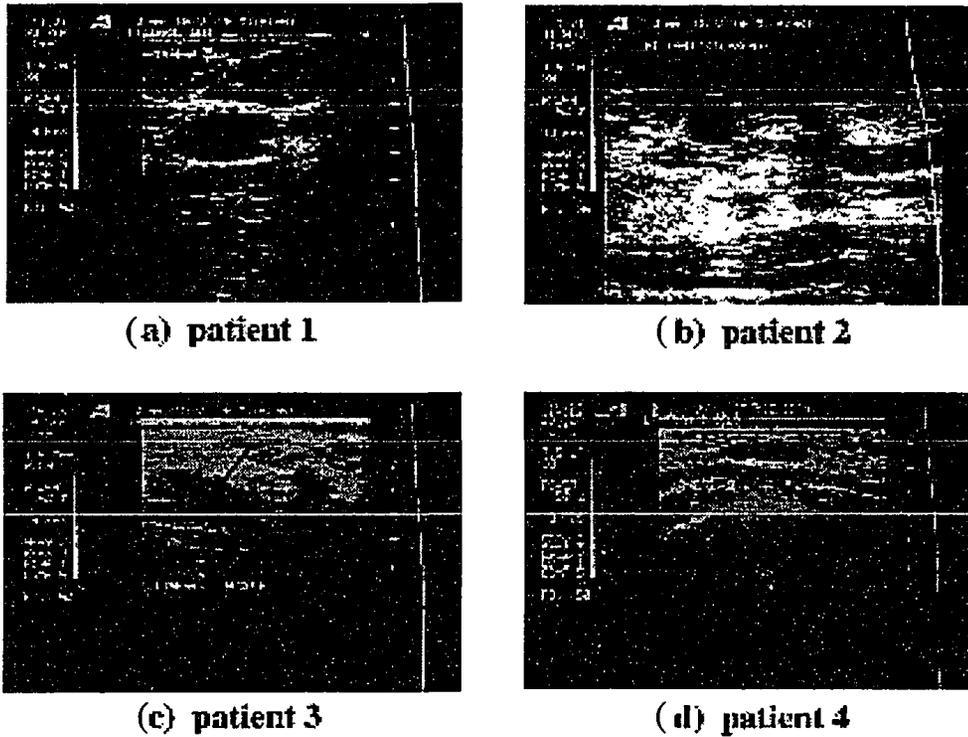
Ultrasound images for patients 1-4.
